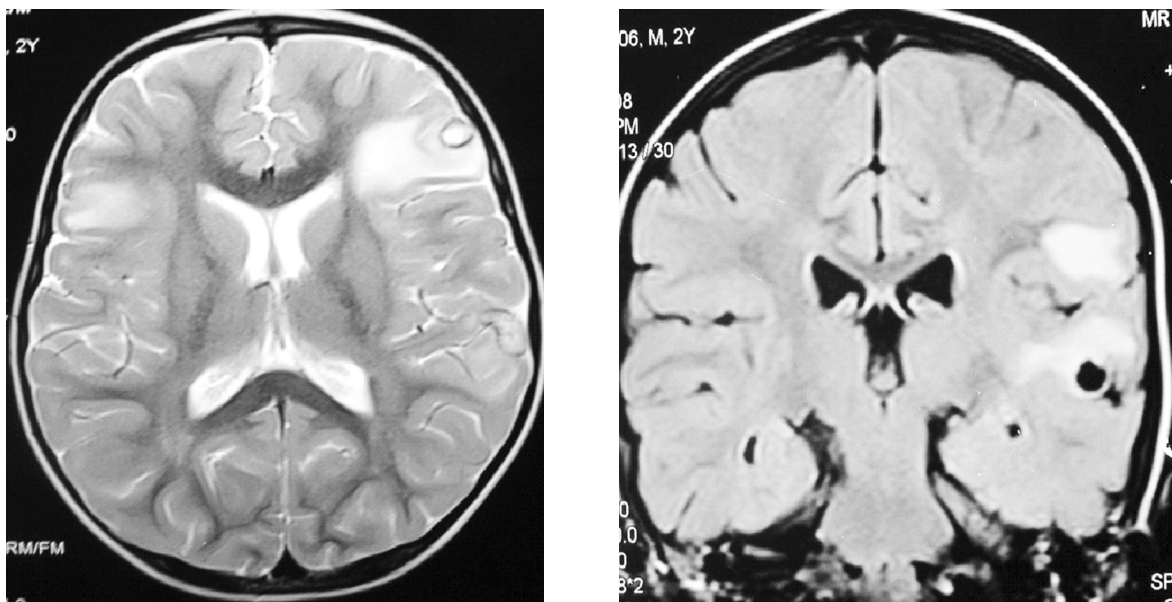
MRI showing ring lesion with perilesional oedema
